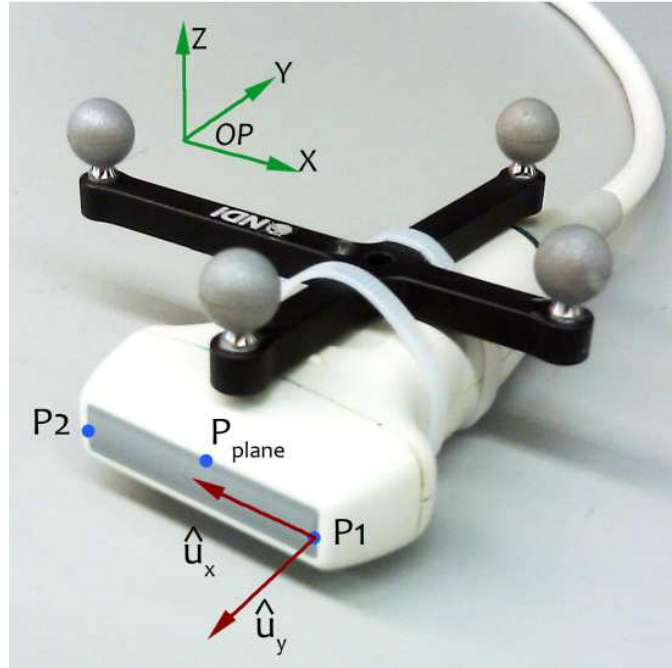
The tracked linear ultrasound probe used in the developed system, showing the collected calibration measurements, and the calculated calibration parameters
